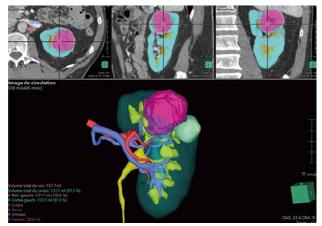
3D reconstruction by segmentation of the preoperative CT-scan using Vincent software (Fujifilm)
